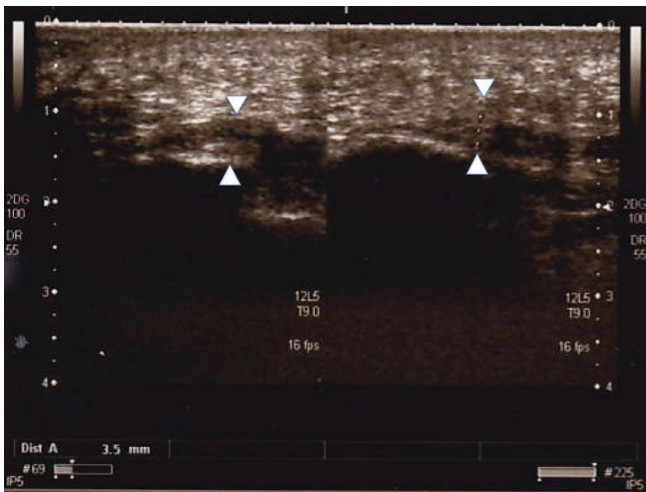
Follow-up ultrasound scan after 12 days, clinical case 2: Reduction in the hypoechoogenicity at the insertion of the right plantar fascia
